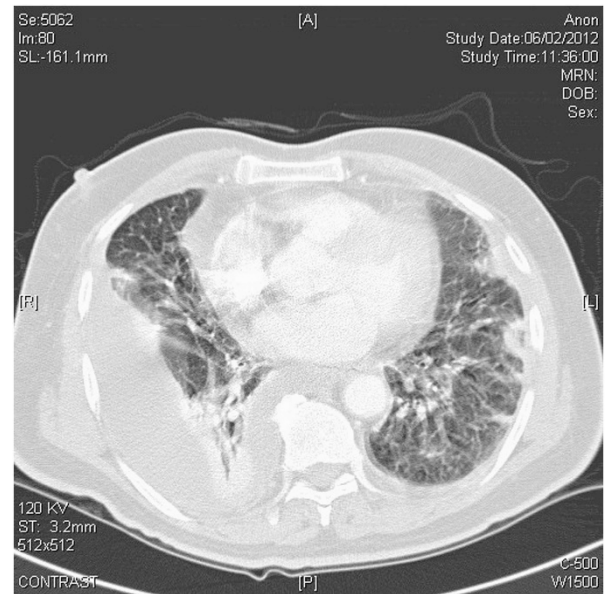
The pulmonary CT angiogram shows left-sided dependent pleural effusion and a greater right-sided loculated effusion with a paraspinal pleural collection.
